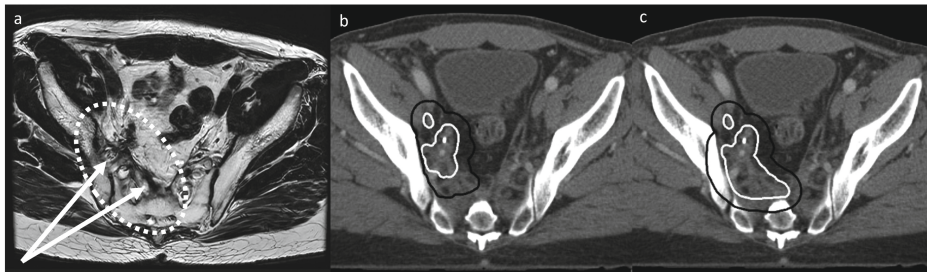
Example of an alteration made during a QA meeting. From left to right, the pre-treatment diagnostic MRI (a), planning CT with pre-QA target volumes (b) and planning CT with post-QA target volumes (c) are shown. The GTV is shown in white, the CTV in black. The original GTV was extended following QA to encompass the complete fibrosis. The CTV was originally edited out of the bone, but it was advised not to do so given the invasive nature of the disease and the risk of an R1-resection at the lateral side wall.
